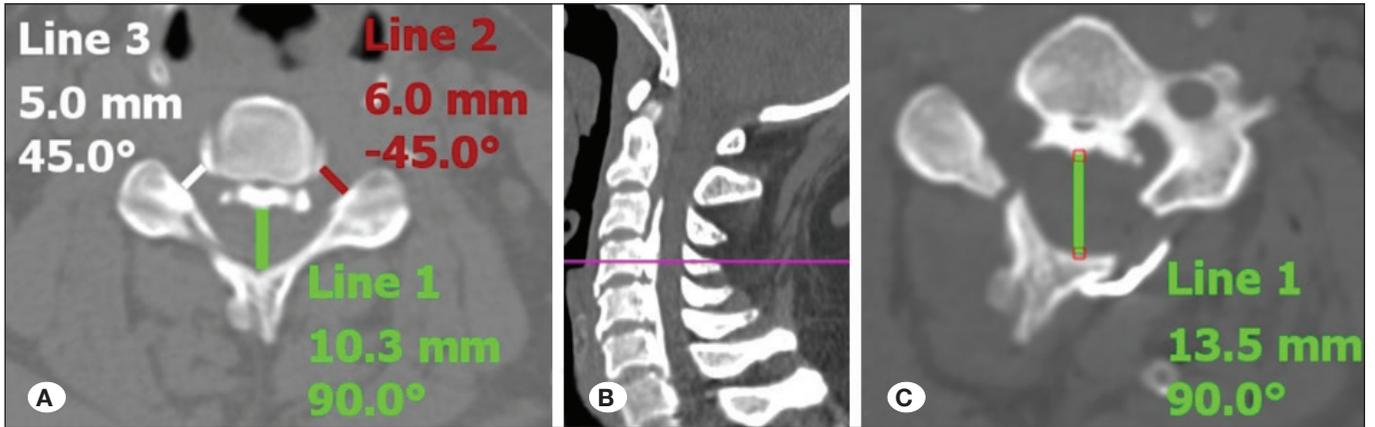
A) Preoperative axial cervical CT; Line 1 (green arrow); The anteroposterior (AP) distance of the spinal canal at the C4/C5 level. Line 2,3 (red-white arrow); The transverse distance of the C4/5 foramen. B) Sagittal cervical CT line demonstrate the level of figure A and C. C) Postoperative axial cervical CT; Line 1 (green arrow): The anteroposterior (corpus posterior-lamina anterior) distance of the spinal canal at the C4/C5 level.
